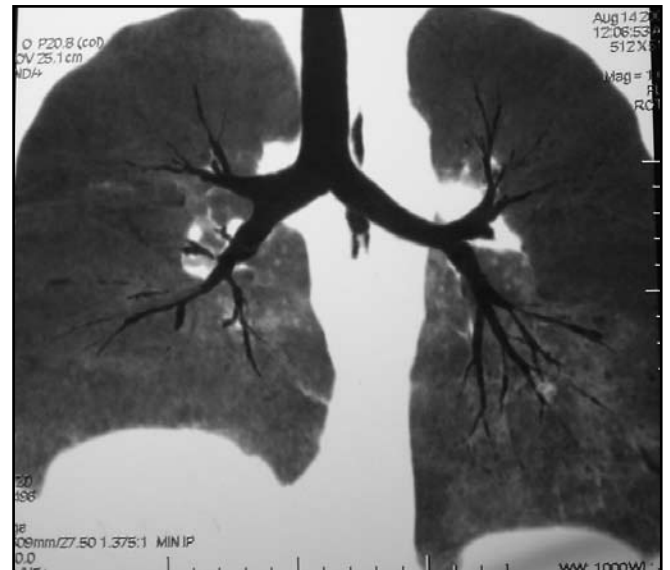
Computed tomography angiography of the chest.
